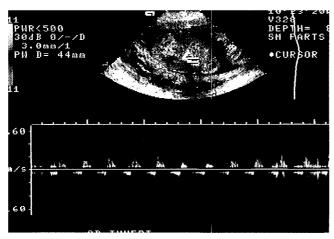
Right fetal leg. Pulsed Doppler demonstrating arterial flow beneath the constriction ring. Arterial flow could not be demonstrated at 24 and 28 weeks' gestation.
